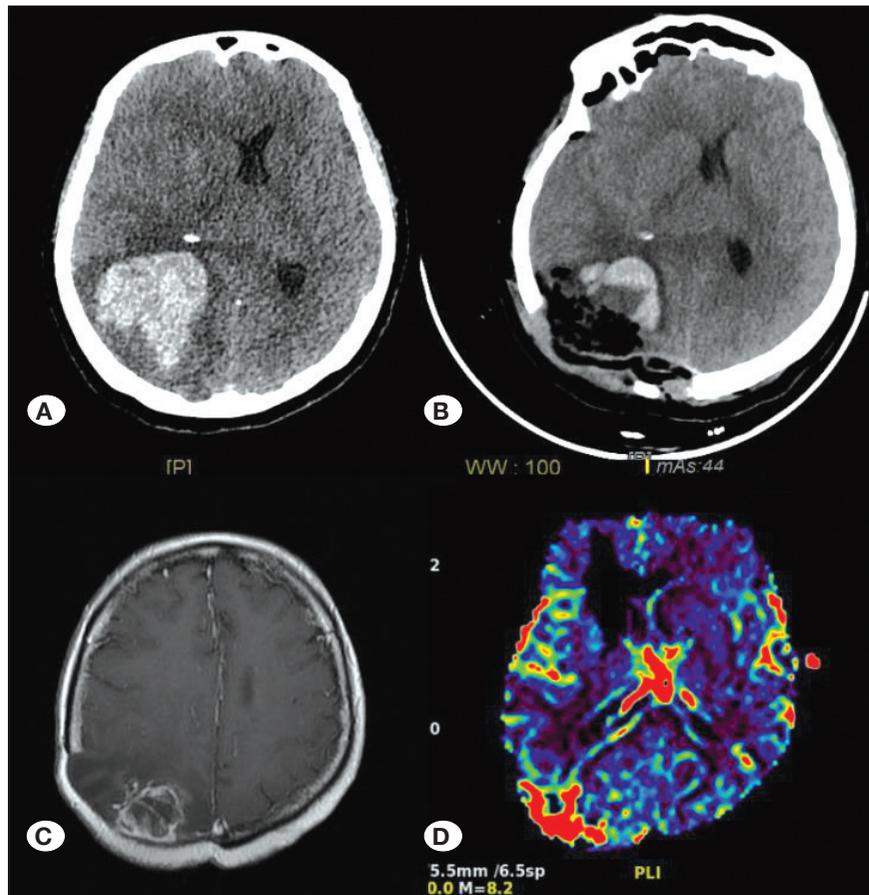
A) Preoperative axial cranial computed tomography (CCT) image, B) postoperative axial CCT image, C) T1-weighted contrast enhanced axial magnetic resonance imaging (MRI) one-month after surgery, and D) perfusion weighted axial MRIs at postoperative second month.
